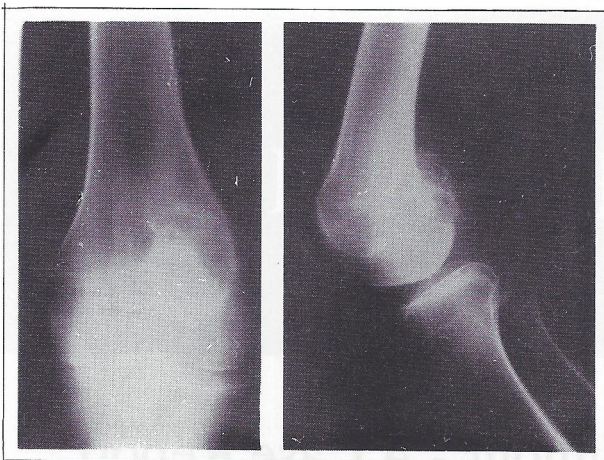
The anteroposterior and lateral radiograph of the knee demonstrating a giant cell tumour in the medial femoral condyle extending posteriorly.*
